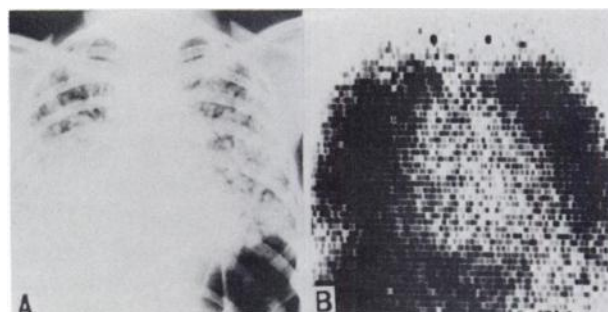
(A) Chest x-ray shows numerous shadows of varying sizes in entire lung field. (B) Scintigram with ^{67}Ga -citrate is positive in entire lung field similar to pulmonary scintigram with ^{131}I -MAA.
